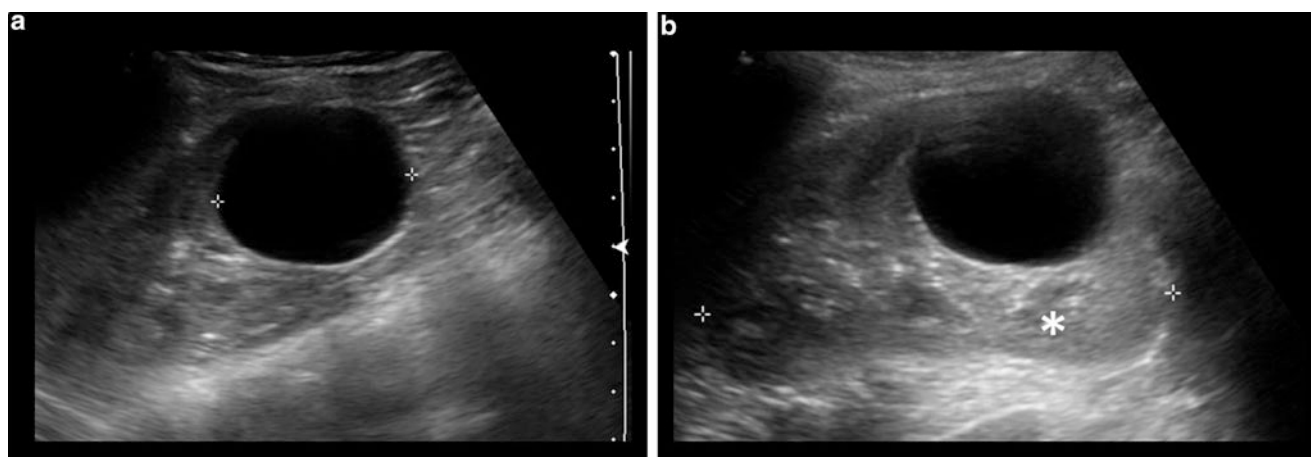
Renal ultrasound showing simple renal cyst. (a) The cyst is a well-defined, rounded structure with imperceptible wall thickness and lack of internal echoes. (b) Posterior enhanced through transmission is a characteristic sonographic finding (*asterisks*)
